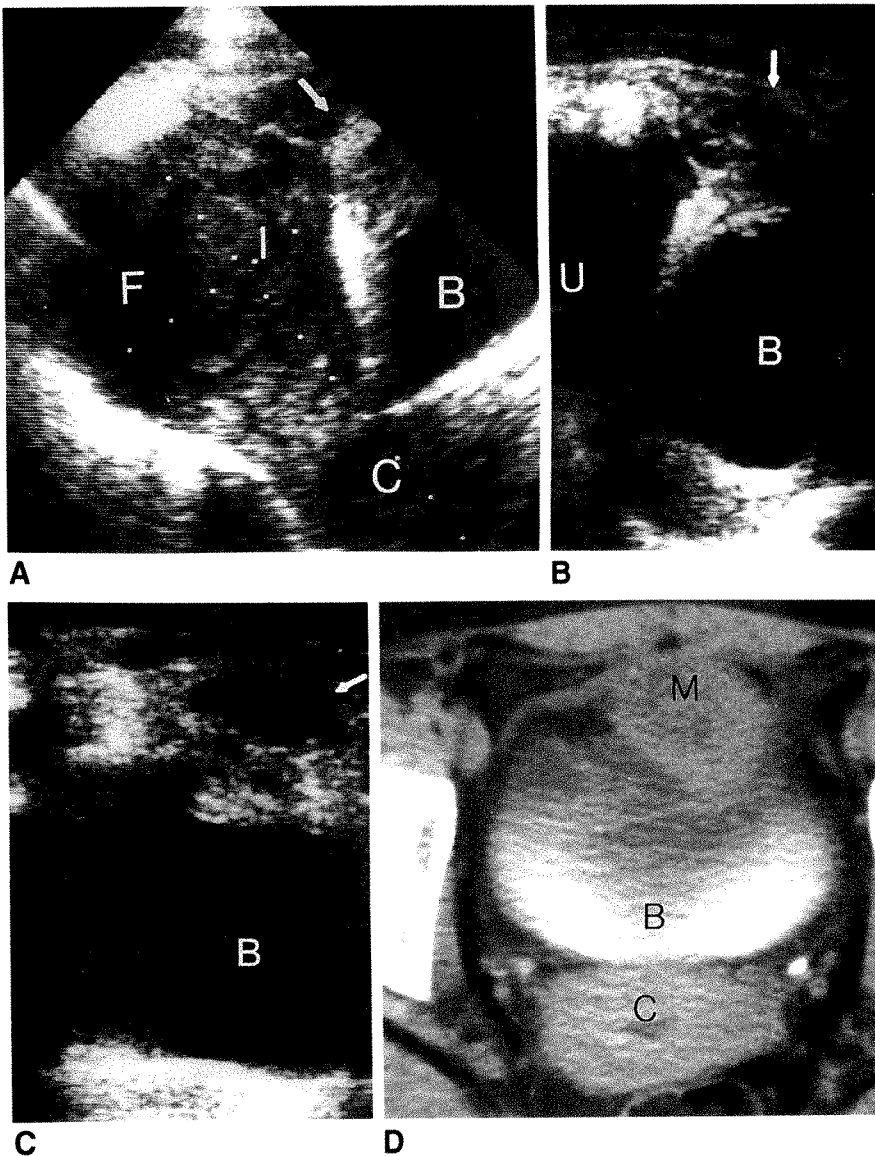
A, Sagittal sonogram reveals a mass (arrow) in dome of bladder (B). Fibroids and a component of inflammatory infiltrate (I) are noted in anterior portion of uterus. Bright echoes posterior to mass were thought to represent bowel gas. C = cervix, F = uterine fundus.
